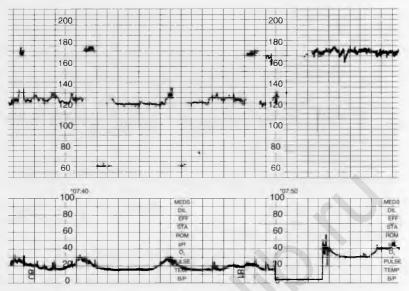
Maternal (120 bpm) and fetal (170 bpm) tachycardia - ultrasound mode.
